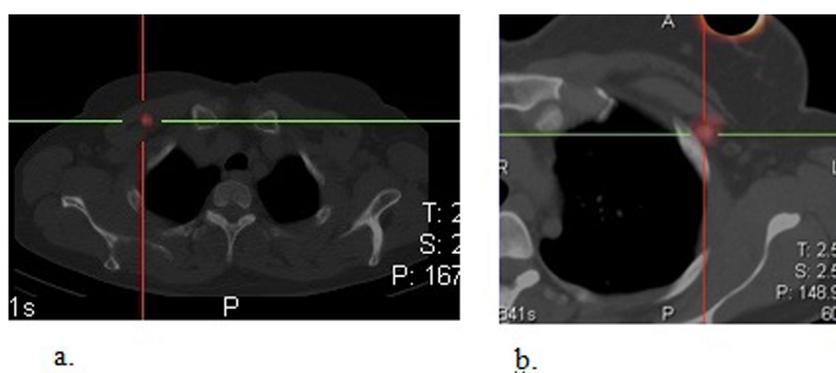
Fused SPECT-CT axial images of pectoral sentinel lymph nodes. (a) Sentinel lymph node located between the pectoral muscles. (b) Subpectoral sentinel lymph node.
